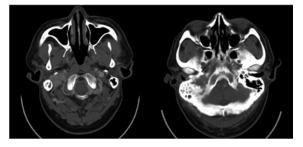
CT Temporal bone with contrast showed enhancing mass at the right jugular foramen with extension to right mastoid cavity and right upper neck.
